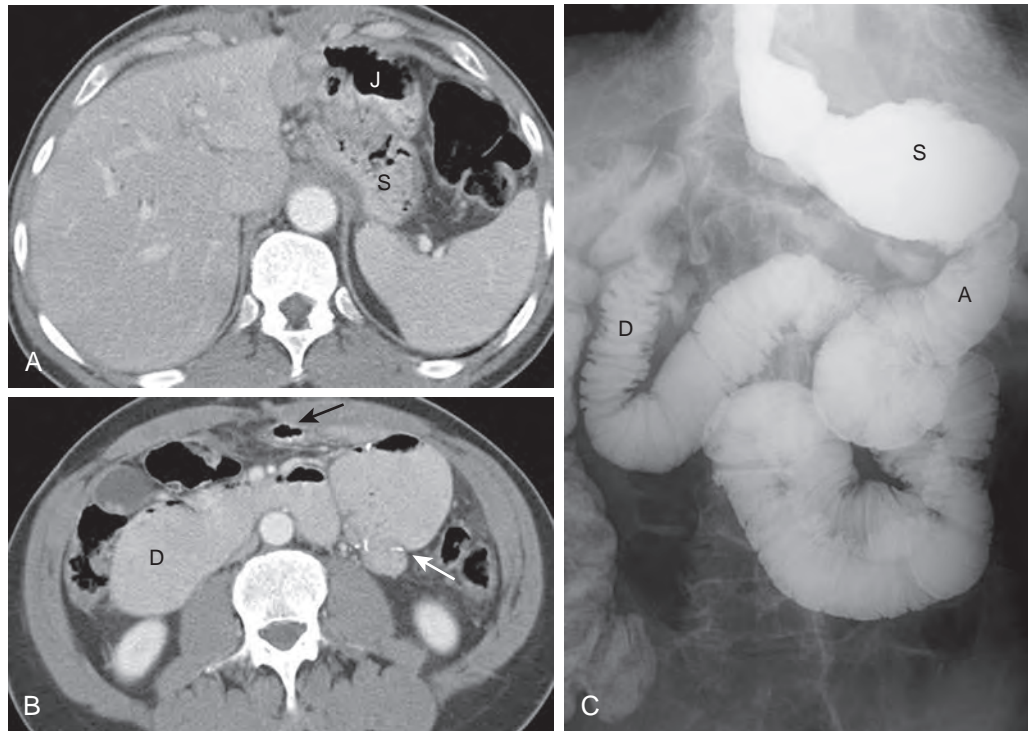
Afferent loop syndrome following Roux-en-Y gastrojejunostomy. A, B. Axial-contrast enhanced CT images A. A small gastric remnant (S) is anastomosed to a jejunal Roux limb (J). B. There is a small bowel anastomosis in the left midabdomen (white arrow). The afferent limb is markedly dilated and fluid-filled, with distention of the duodenum (D). The efferent jejunal limb is decompressed (black arrow). C. Overhead radiograph following UGI shows a dilated gastric remnant (S) with reflux into the esophagus. There is preferential filling of a dilated afferent limb (A) and duodenum (D). Note contrast in the right colon from a prior study.
